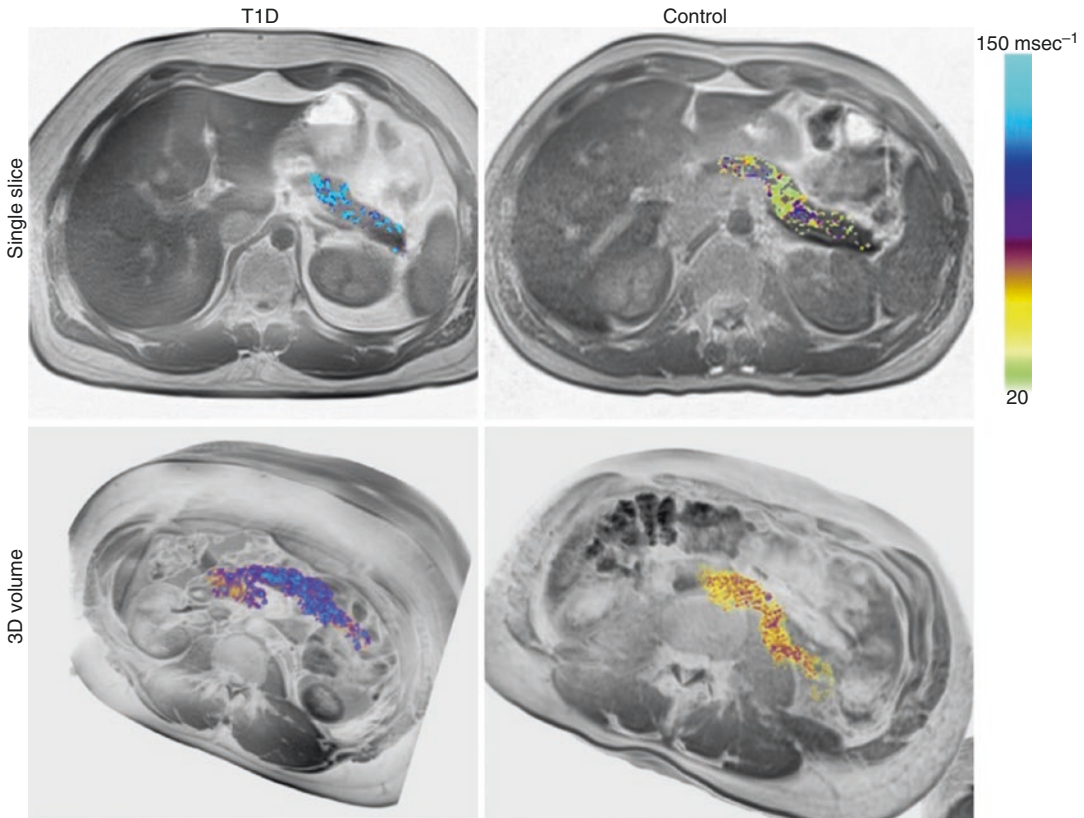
MRI imaging of insulinitis. The iron replacement therapy agent ferumoxytol accumulates in macrophages. The increase in $\Delta R2^*$ is higher in the pancreas of recent-onset type 1 diabetic patients (*left*) than the controls
